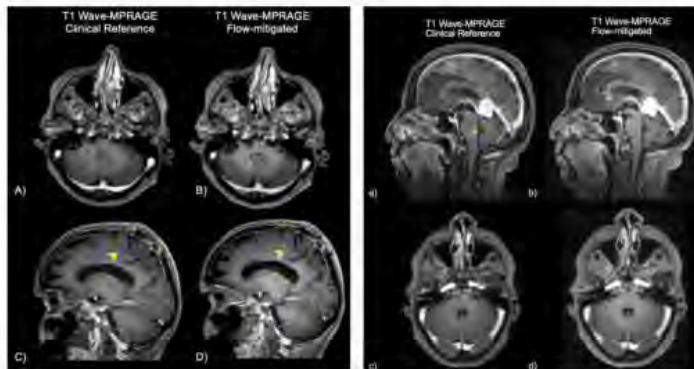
Representative images of an 82-year-old male with progressive multifocal leukoencephalopathy (PML) showing a small focus of apparent enhancement (arrows) on A) axial and C) sagittal views of conventional T1-weighted post-contrast Wave-MPRAGE imaging. No enhancement was noted on the corresponding B) axial and D) sagittal flow-mitigated Wave-MPRAGE images, suggesting that the area of apparent enhancement was consistent with flow-related artifact. Curvilinear enhancement is also seen in the posterior frontal lobe subcortical U-fiber (arrowhead) corresponding to a white matter demyelinating process associated with the patient's known diagnosis of PML.
